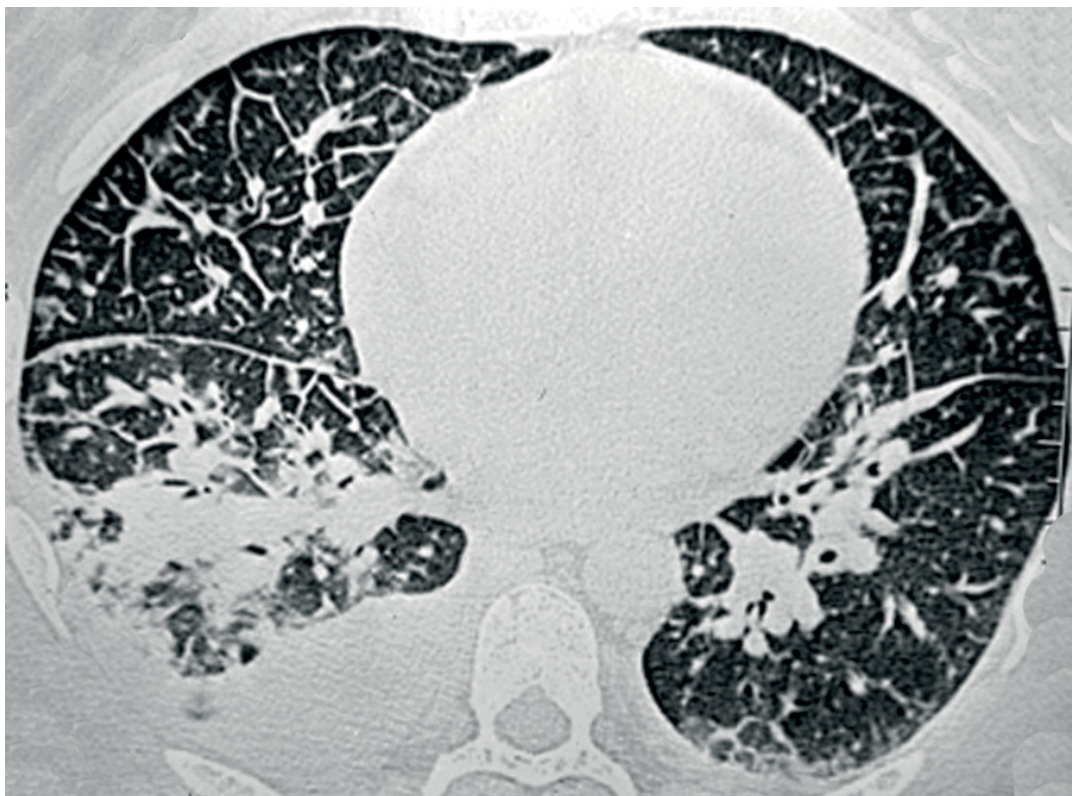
Axial CT image obtained at the level of the lower lobes and showing interlobular septal thickening, consolidation in the right lung, and bilateral pleural effusion.
